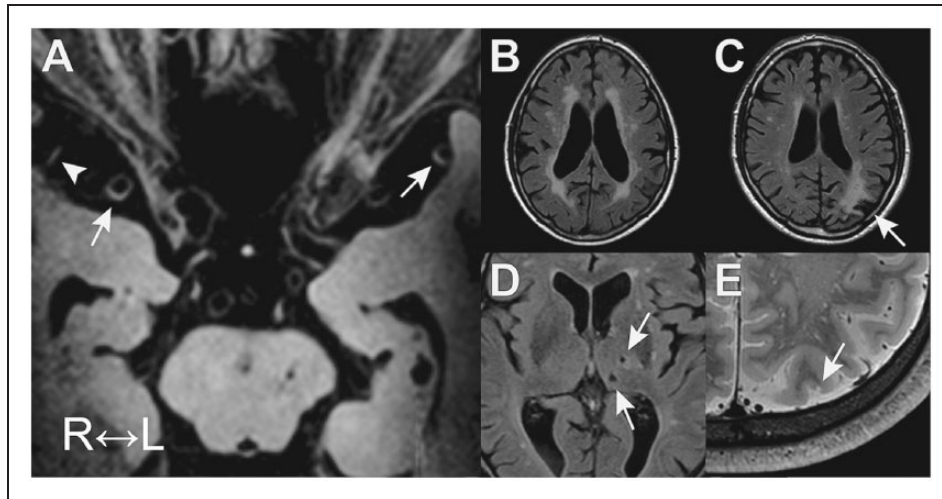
Examples of intracranial vessel wall lesions on 7T vessel wall MRI (a) and associated parenchymal lesions (b) to (e). (a): Vessel wall lesions in the M1 segment on both sides (arrows) and M2 lesion on the right (arrowhead); (b): periventricular white matter hyperintensities; (c): cortical infarct (arrow); (d): lacunes of presumed vascular origin (arrows); and (e): cortical microinfarct (arrow).
